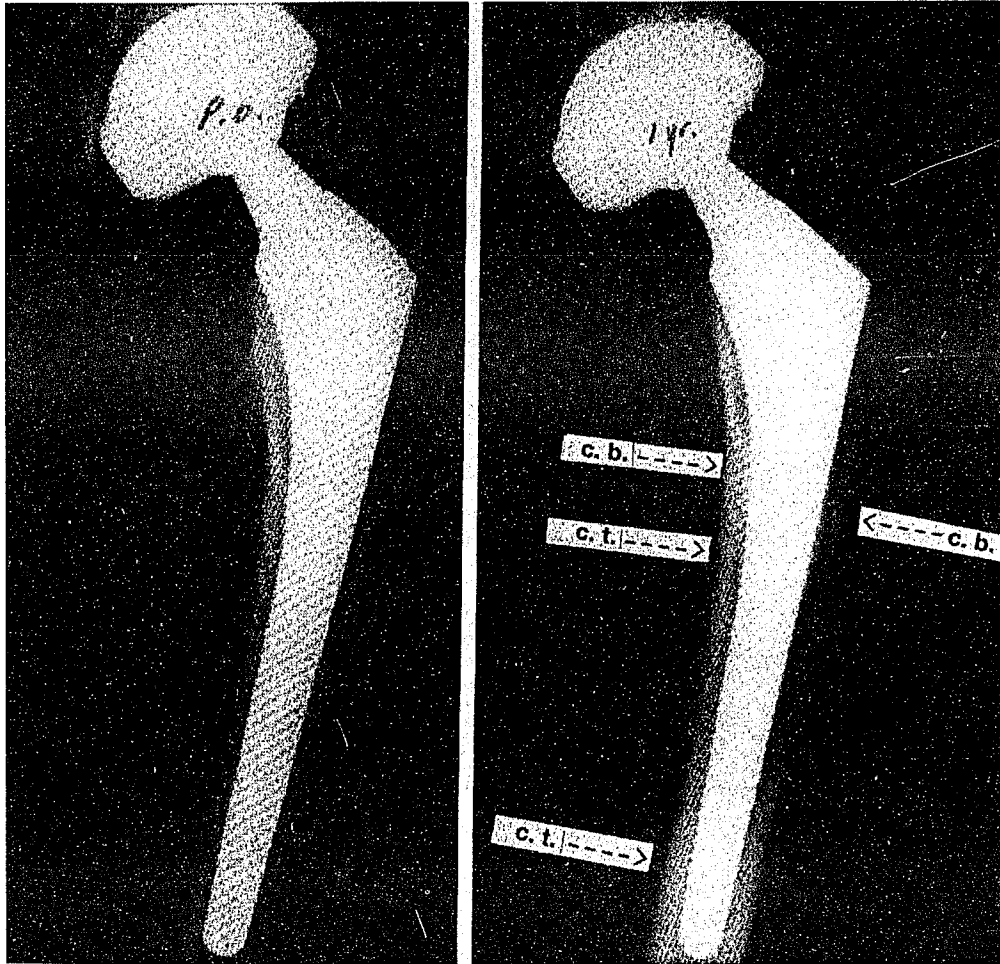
In this patient, cancellous-bone (c.b.) formation is seen both one and two years postoperatively. Cortical thickening (c.t.) is present at the middle and the distal medial portion of the stem at one year and progressed at the two-year follow-up. Radiolucencies (r.l.) are found only around the distal portion of the tip of the stem. (a) and (b): Anteroposterior radiographs made soon postoperatively and one year postoperatively. (from fig. 6, D'Antonio *et al.* 1992).
